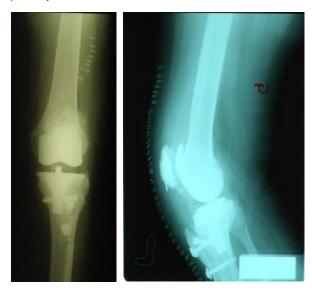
Postoperative X-ray after tibial tuberosity transfer and lateral release and patellar resurfacing
